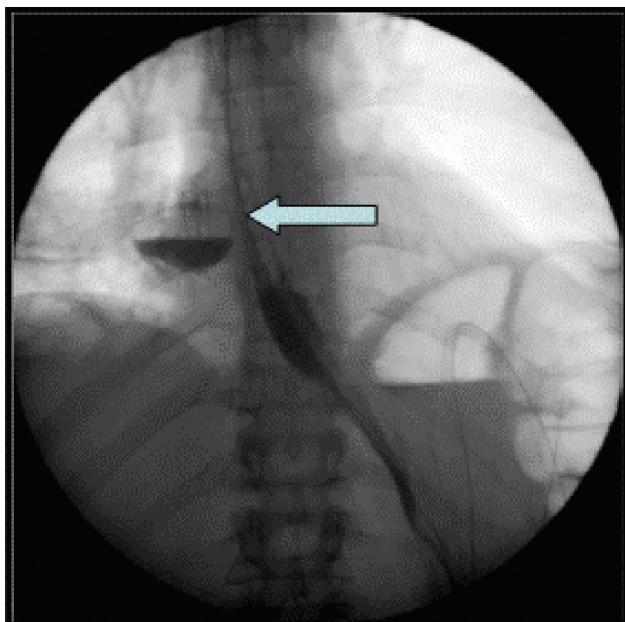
Contrast collection with air-fluid level in the postero-medial region of the right hemithorax shown on the esophageal passage radiography taken on the 7th postoperative day – an esophageal fistula.
